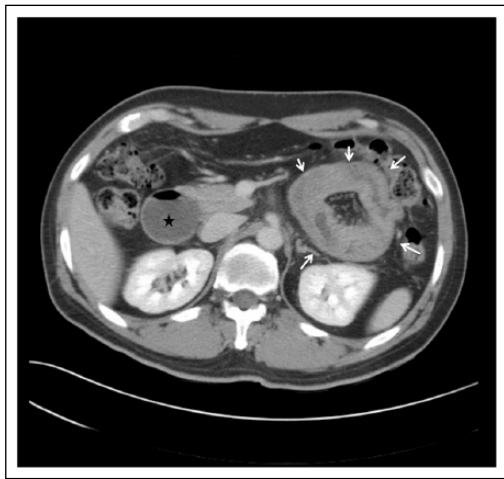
Axial contrast-enhanced computed tomography image showing obstructed left paraduodenal hernia as a cluster of small bowel loops in the left paraduodenal fossa (white arrows) and proximately dilated duodenum (black star).
